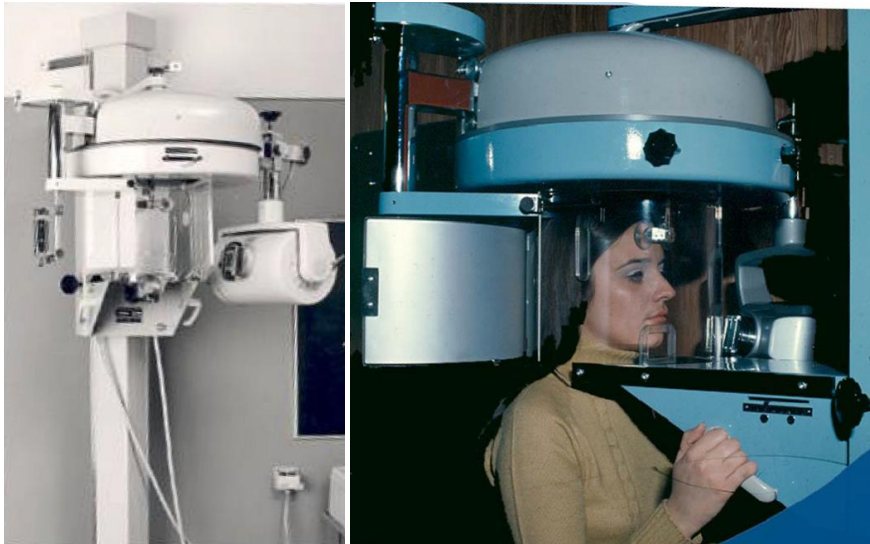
The Orthopantomograph OP2 (1964-1972, Instrumentarium, Tuusula, Finland) featured an improved imaging geometry and a redesigned, curved cassette. Courtesy of Instrumentarium Oy and J. Mudrak.
